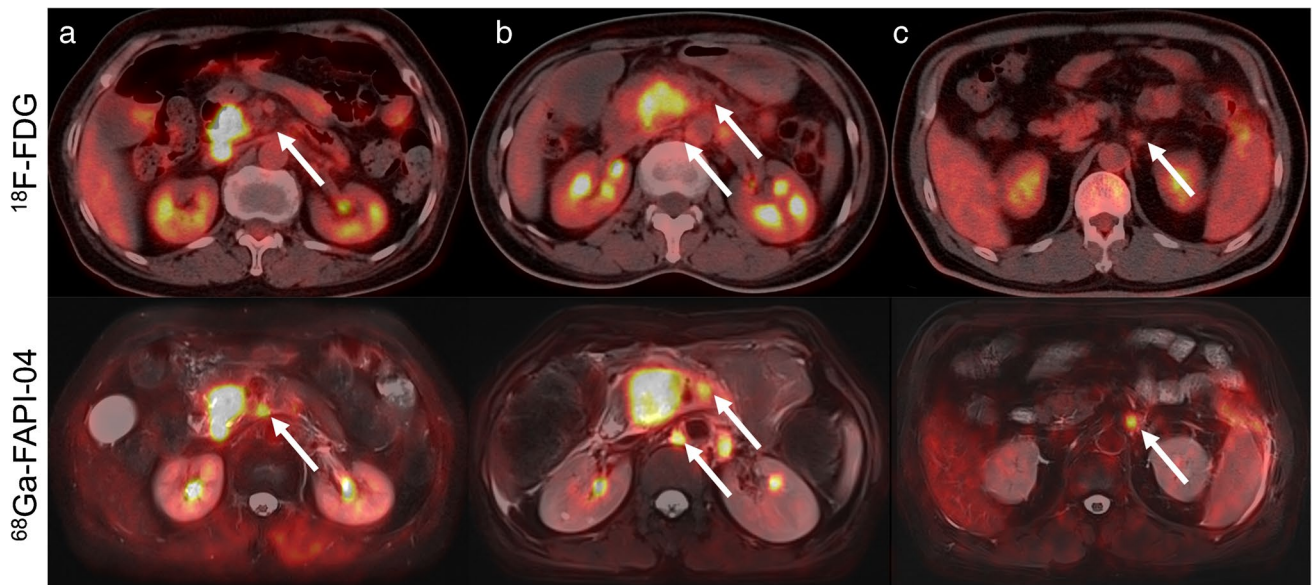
In these three patients, ^{18}F -FDG-negative lymph nodes were ^{68}Ga -FAPI-04 positive (arrows)
